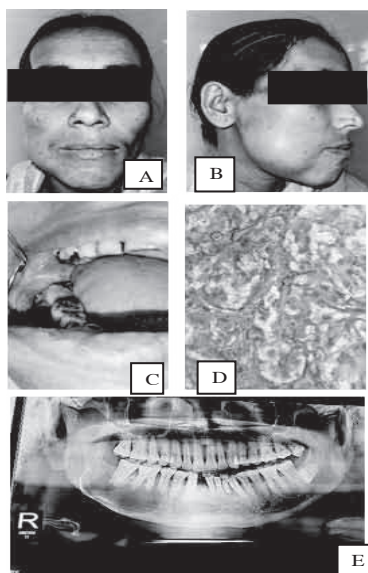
(A) Patient's profile; (B) swelling on Rt side of body of mandible; (C) intraoral picture; (D) H/P view (E) X-ray OPG.
